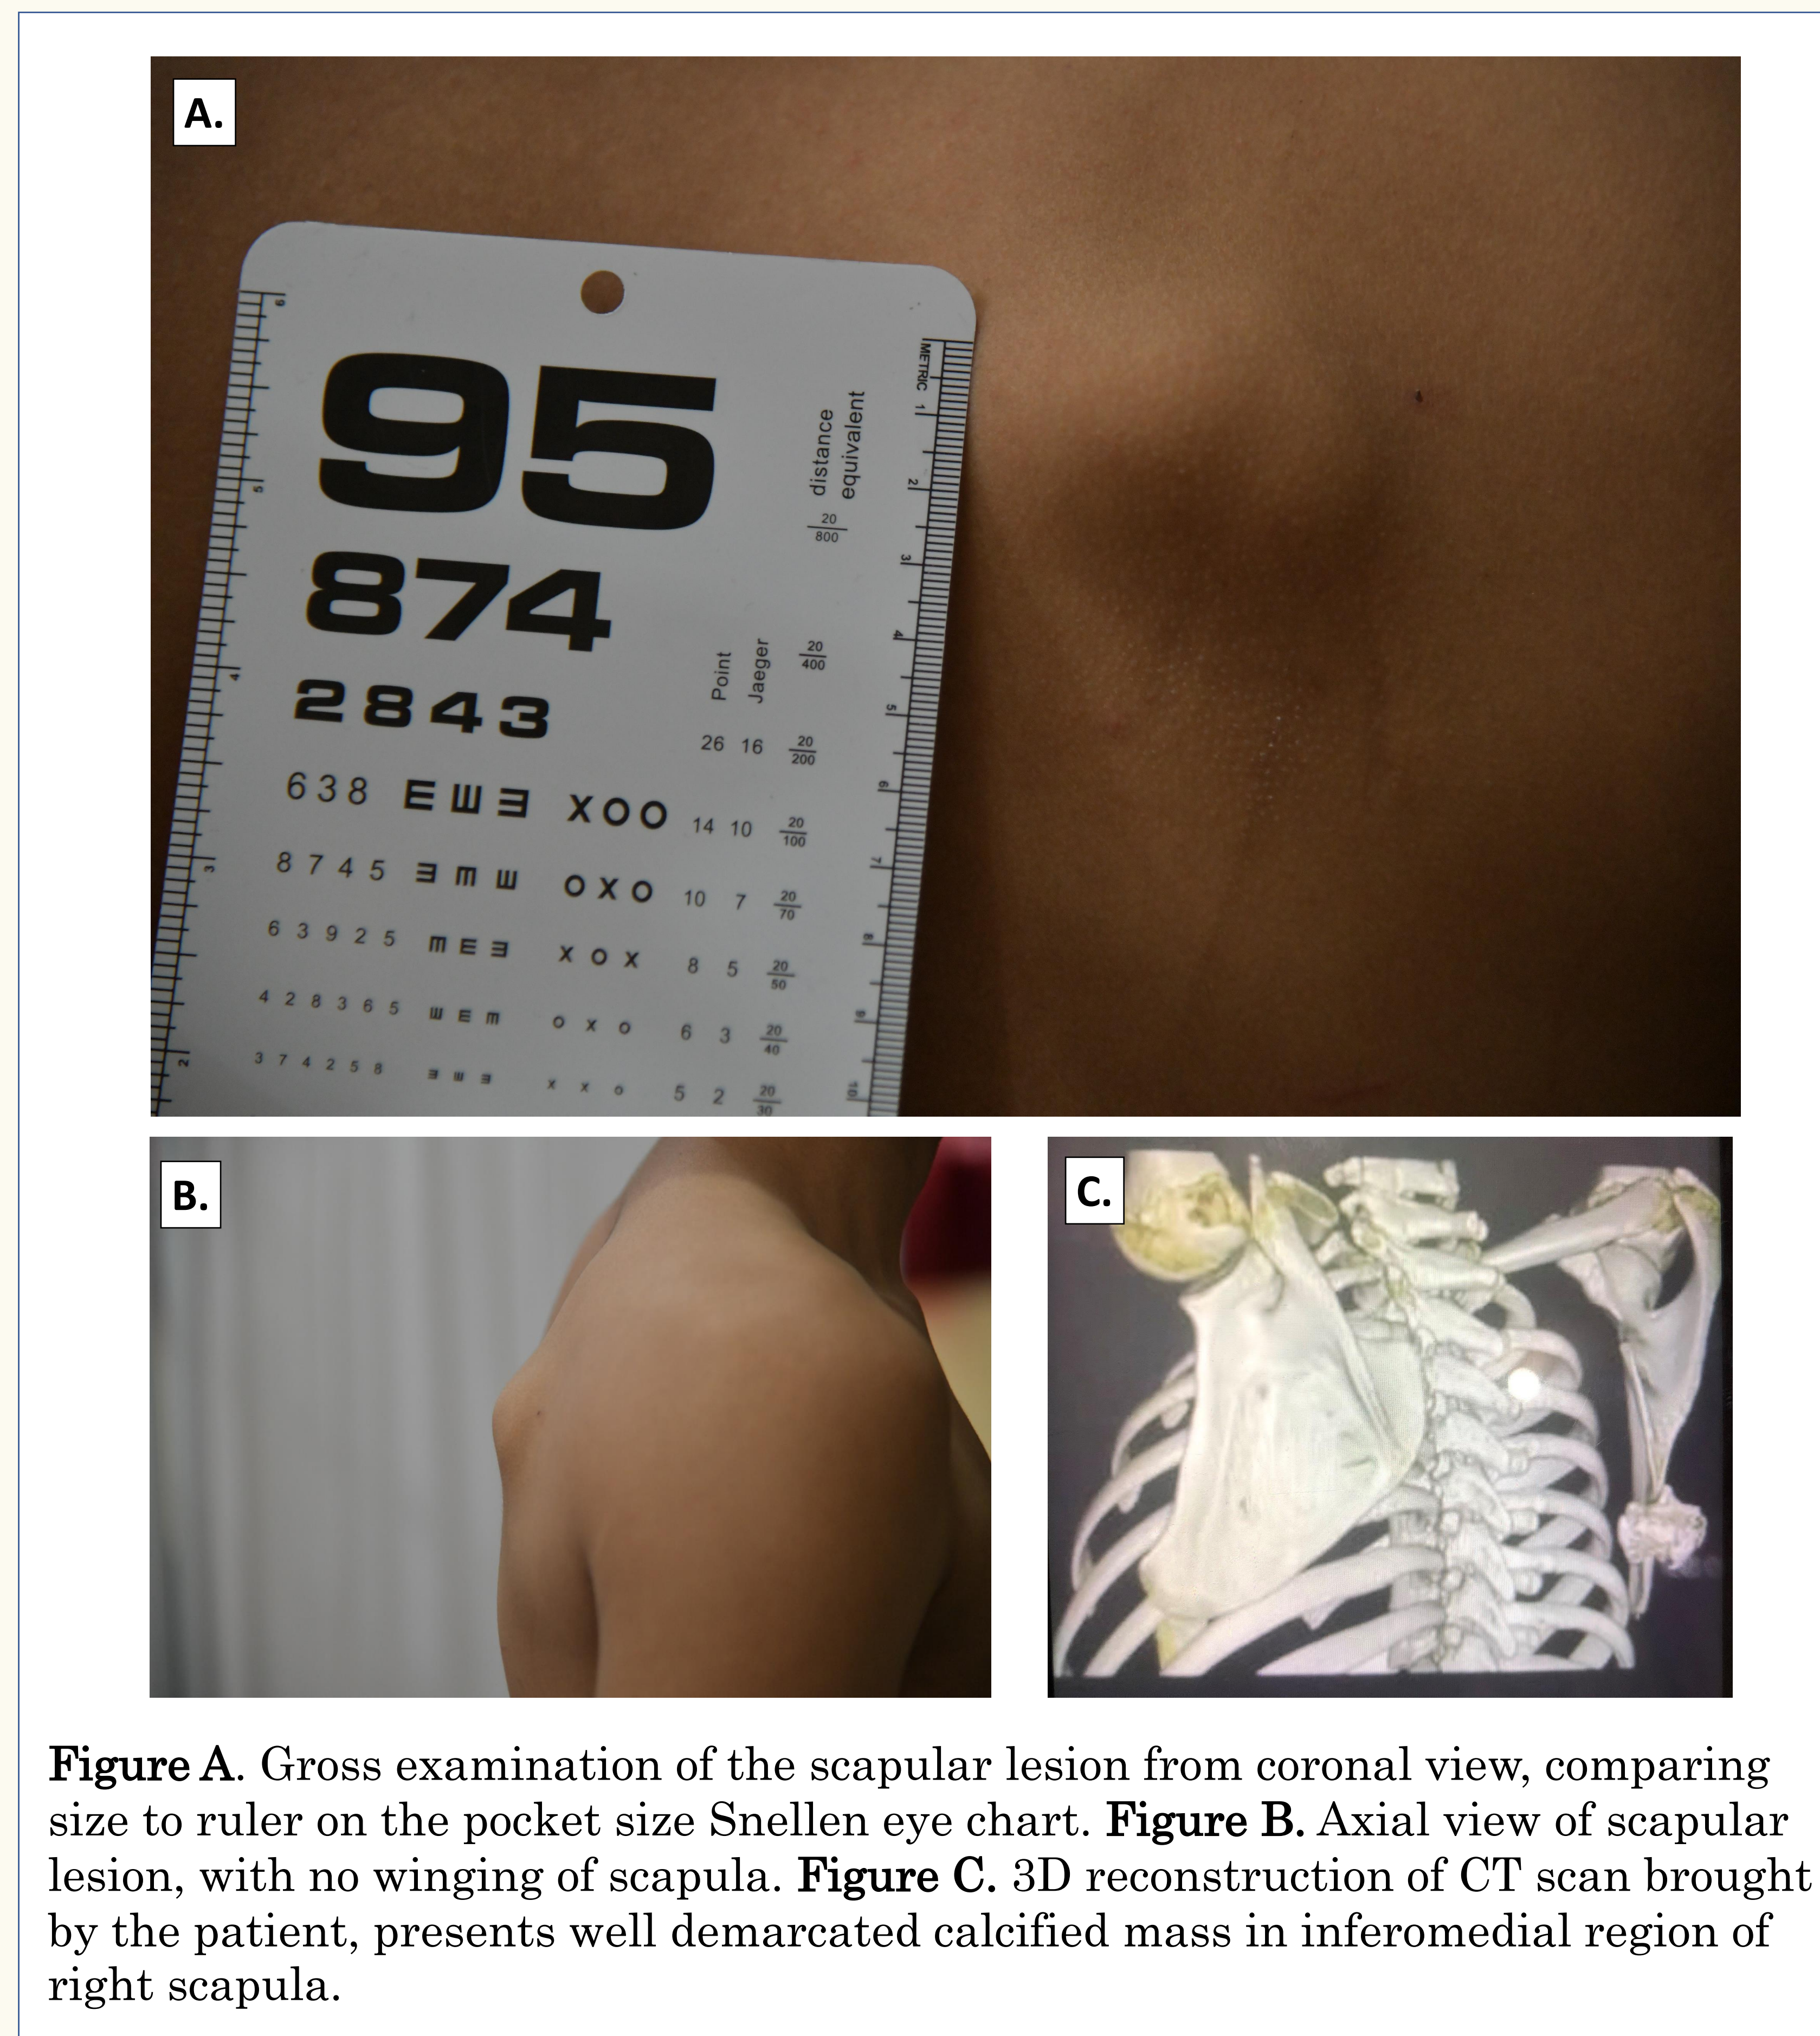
Gross examination of the scapular lesion from coronal view, comparing size to ruler on the pocket size Snellen eye chart. Figure B. Axial view of scapular lesion, with no winging of scapula. Figure C. 3D reconstruction of CT scan brought by the patient, presents well demarcated calcified mass in inferomedial region of right scapula.
